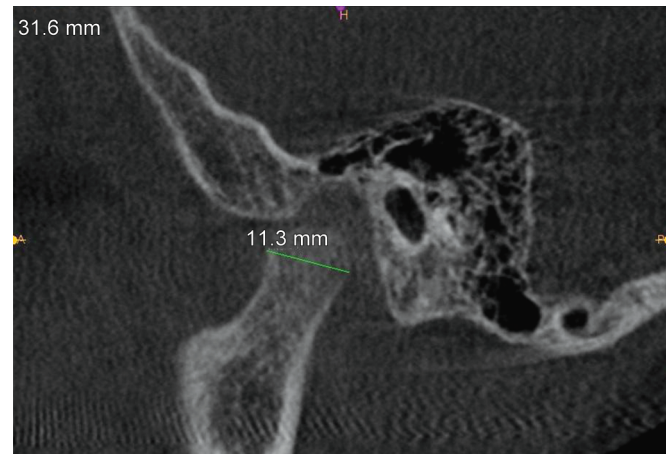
Cone-beam computed tomography (CBCT) scan of condylar length posttreatment
